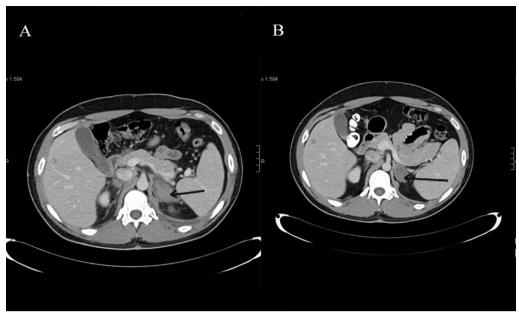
CT Abdomen with contrast, axial images (A) shows bilateral adrenal hemorrhage, (B) Follow up shows decrease in size of the hemorrhage, Arrow towards the left adrenal gland
